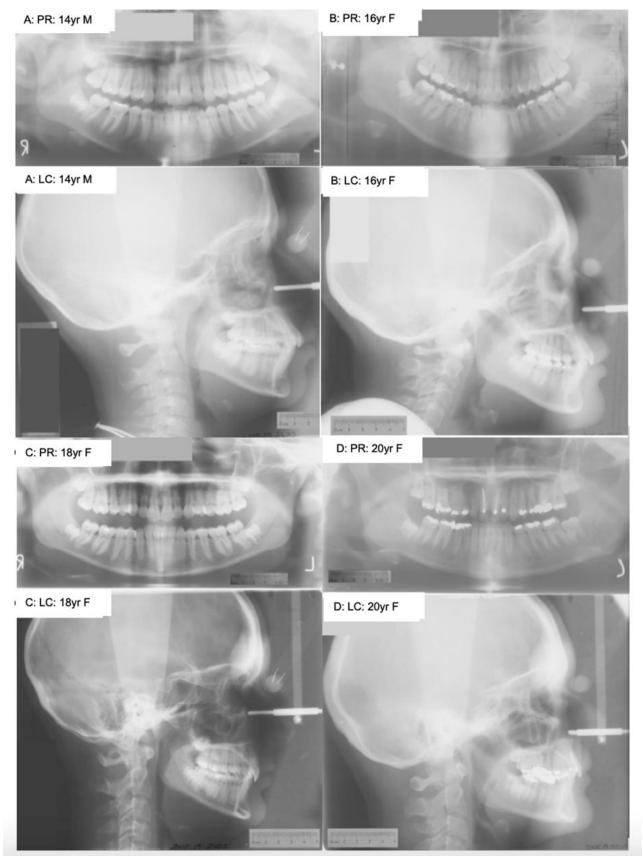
Example of PR and LC radiographs of individuals afed 12 to 20 years, *A*: 14yr M, B: 16yr F, C: 18yr F, D: 20yr F.
